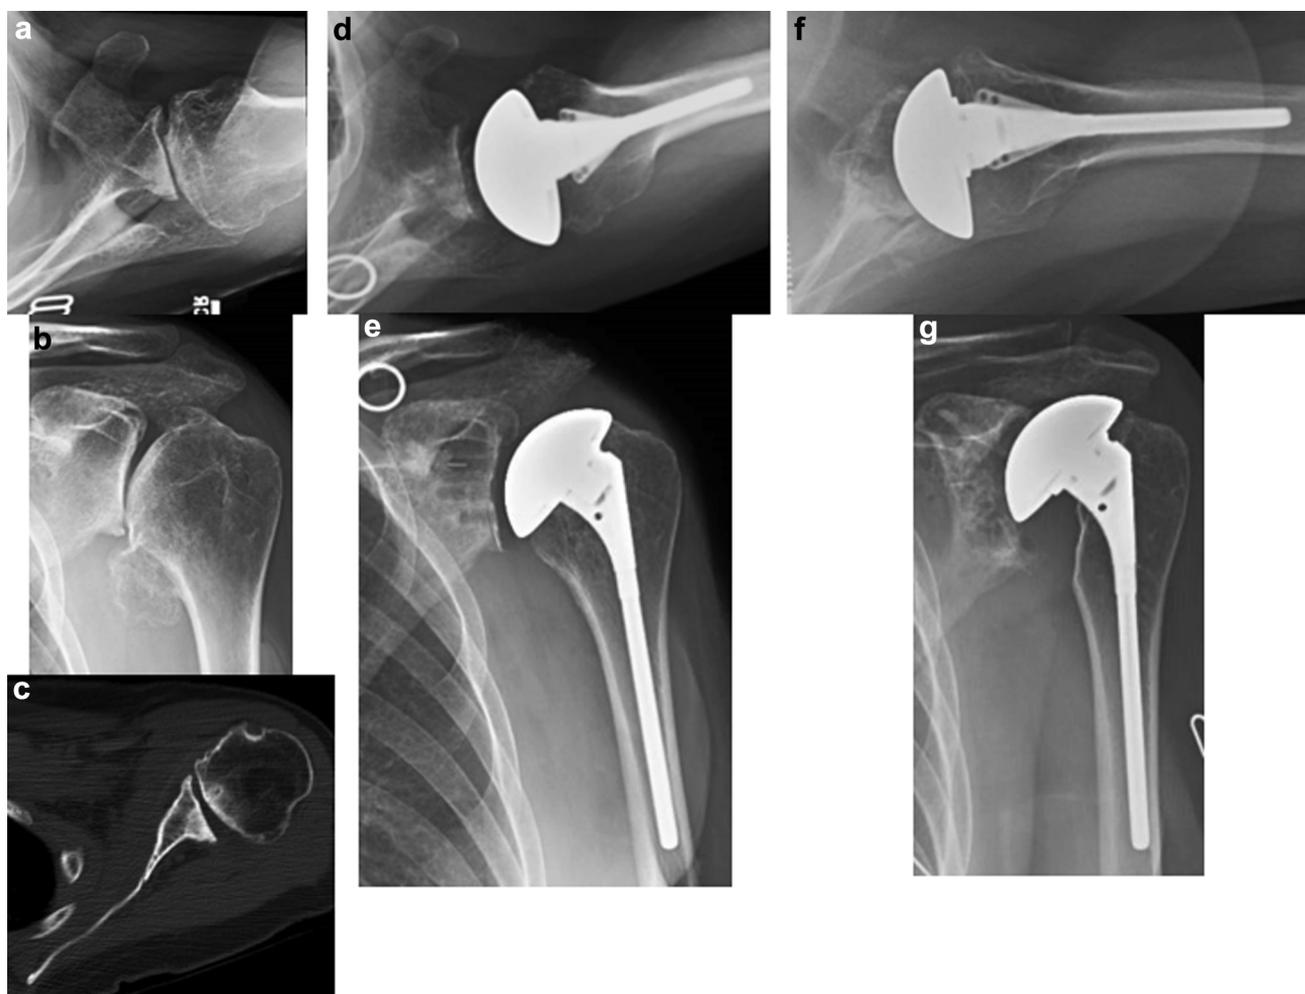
Imaging of a 66-year-old female patient with severe osteoarthritis. (a) Preoperative anteroposterior radiograph. (b) Preoperative axillary radiograph. (c) Preoperative mid-axial computed tomography scan, demonstrating 23° of retroversion. Comparison of the initial postoperative (d, e) and 89-month follow-up (f, g) anteroposterior and axillary radiographs demonstrates gross glenoid loosening and grade 3 medial calcar resorption.
